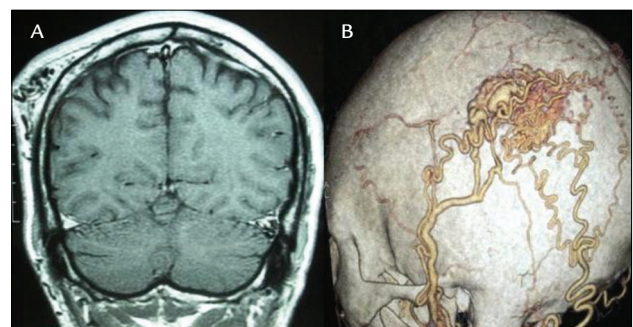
A. Coronal T1-W MRI showing the scalp AVM on the left parieto-occipital region. B. Markedly dilated superficial temporal and occipital arteries supplied the nidus; a draining vein can also be seen.
